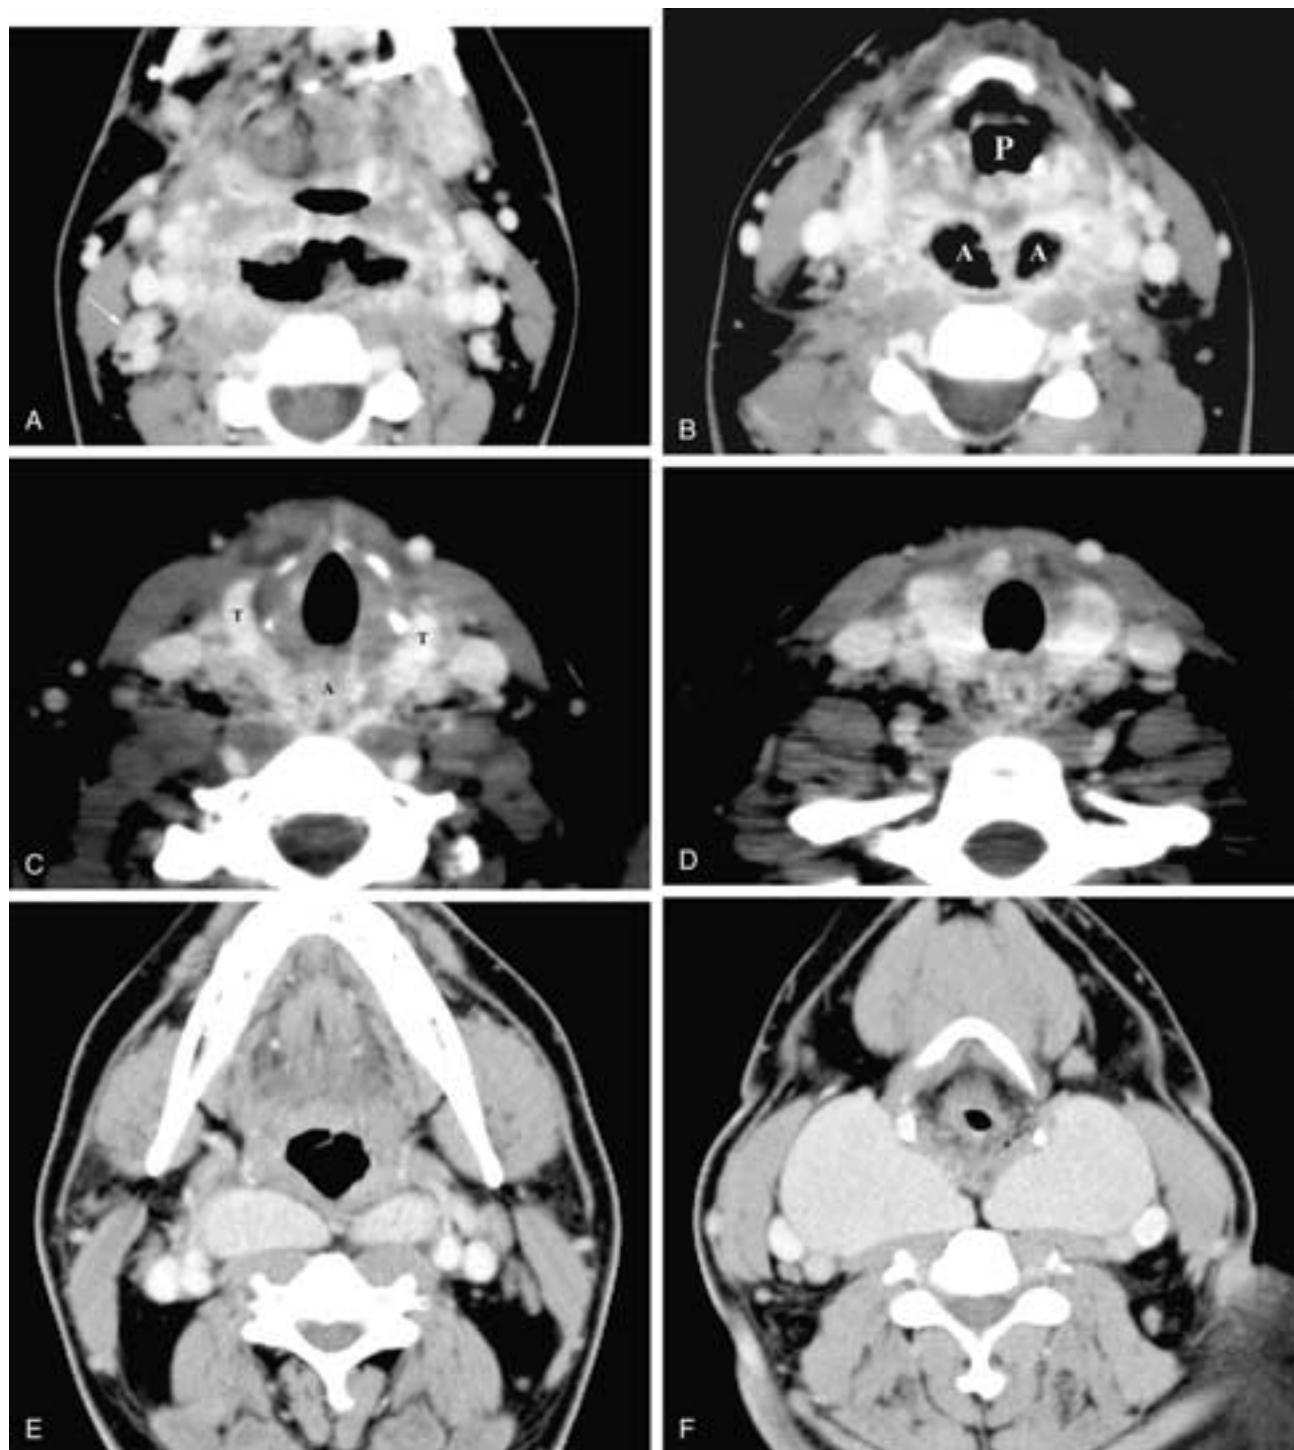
Serial contrast-enhanced CT scans from cranial (A) to caudal (D) show a retropharyngeal abscess with enhancing margins. In A, the abscess is behind the oropharynx and a necrotic inflammatory right level II node (*arrow*) is present. In B, the retropharyngeal abscess (A) is seen at the level of the upper hypopharynx (P). In C, the abscess (A) is seen involving the posterior aspects of each thyroid lobe (T), attesting to the common visceral space that includes the retropharyngeal portion and the visceral compartment containing the thyroid gland, trachea, and larynx. In D, the lowest portion of the abscess is still seen involving the thyroid lobes. Axial contrast-enhanced CT scans at the level of the oropharynx (E) and the thyroid bed (F) of a patient with a large goiter. The enlarged left and right thyroid lobes extend up behind the pharynx in the visceral (retropharyngeal) space.
